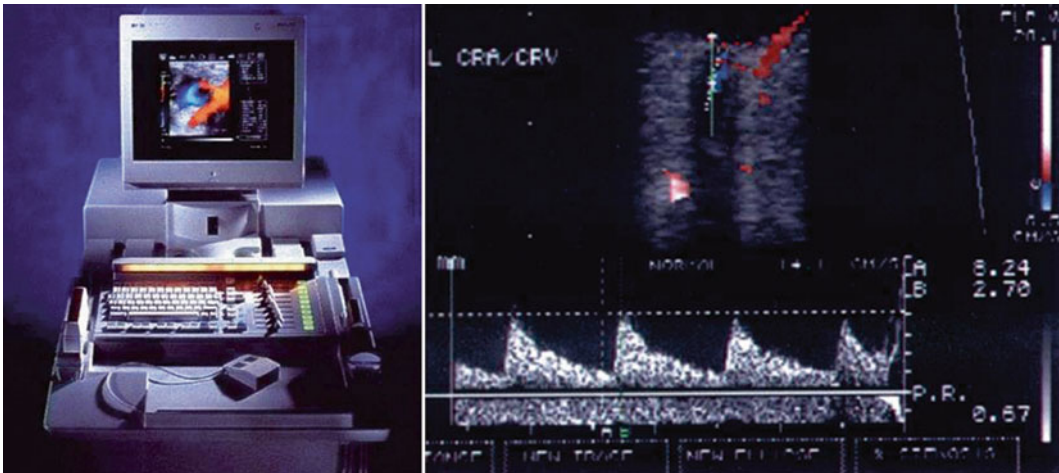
Color Doppler imaging. The *left* picture: A color Doppler machine. The patient is seated comfortably in a half supine position. An ultrasound probe is placed on the closed eyelid and the optic nerve shadow is identified. The vessels sampled include the ophthalmic artery, central retinal artery, and the nasal and temporal short posterior ciliary arteries. The *right* picture: A color Doppler
